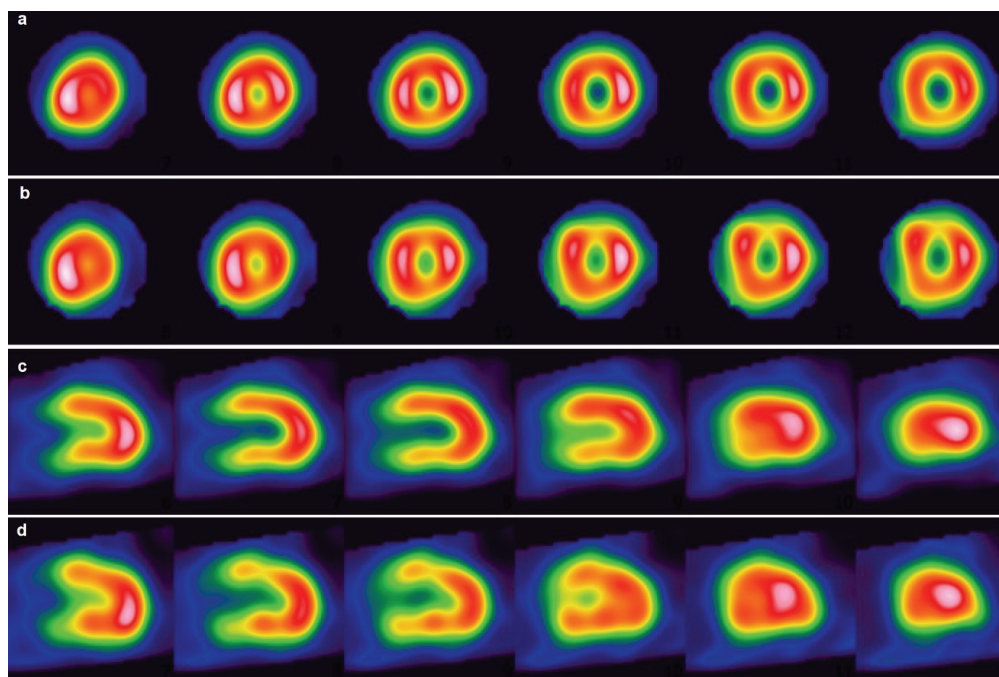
Non-attenuation corrected images (a, c) and CT-based attenuation corrected images (b, d) in short- and vertical long-axis planes. CT-based attenuation correction overcomes the perfusion defect related to diaphragmatic attenuation in the inferior myocardial wall. However, an anterior wall defect occurs as a new artifact
